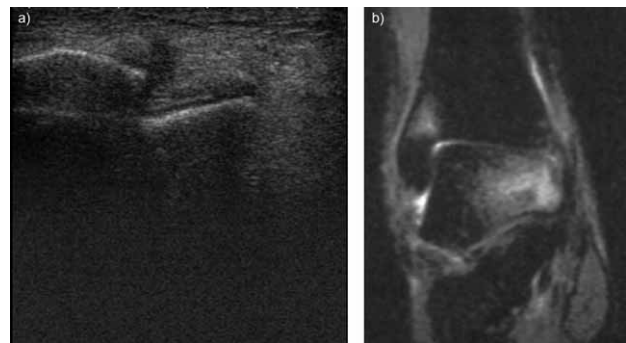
a) (Ultrasound). Rupture (Lesion G3) of the right Anterior talofibular ligament; 6.b) (Magnetic resonance). Rupture (Lesion G3) of the right Anterior talofibular ligament.
